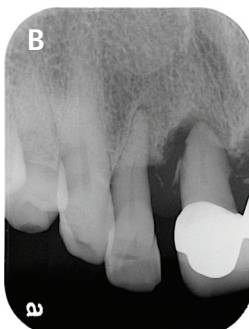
(a) Initial condition with ill-fitting splinted crowns on maxillary bilateral central incisors. (b) Periapical film showed severe periodontal destruction. (c) CT image showed insufficient labial bone width.
